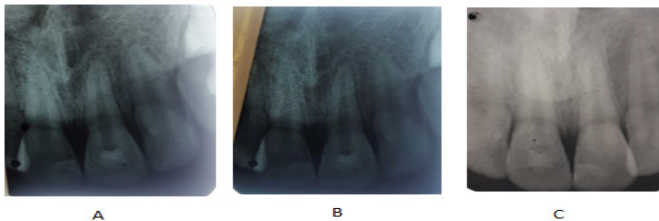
1-month (A), 3-month (B) and 9-month (C) follow-up radiographs.
